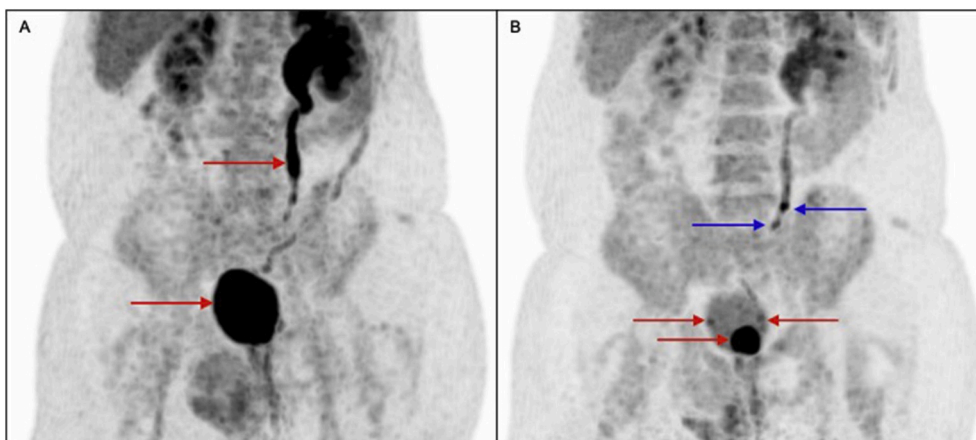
The adequate surgical planning required investigation of a possible multifocal tumor with extension to the ureter; therefore, an 18F-FDG PET/CT was performed. A) The routine 18F-FDG PET/CT coronal image shows only intense physiologic radiotracer elimination in the left dilated ureter and the bladder (arrows). B) However, the delayed 18F-FDG PET/CT images performed after the adequate protocol composed of hyperhydration, diuretics, and voiding identified three focal areas of hypermetabolism in the bladder. These regions corresponded to one vegetative lesion in the left anterolateral wall (SUV max = 25.9); and two in the posterior bladder wall (SUV max = 6.6) (arrows). The latter two lesions in the posterior bladder wall were not identified previously in the CT scan. Furthermore, delayed 18F-FDG PET/CT images also revealed two foci of increased uptake (arrows) consistent with metastatic spread in the proximal portion of the left ureter (SUV max = 12.5). 18F-FDG PET/CT did not detect signs of locoregional or distant metastases.
